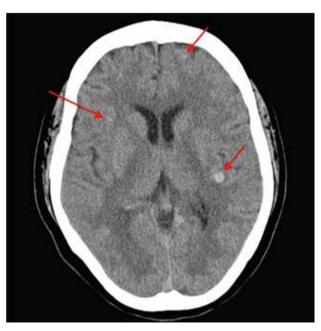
Non-enhanced computed tomography of the brain in axial view, performed in November 2021, showing multiple intra-axial hyperdense lesions (arrows) in the bilateral cerebral hemispheres. Additional lesions are noted in the brainstem and cerebellum (not shown).
